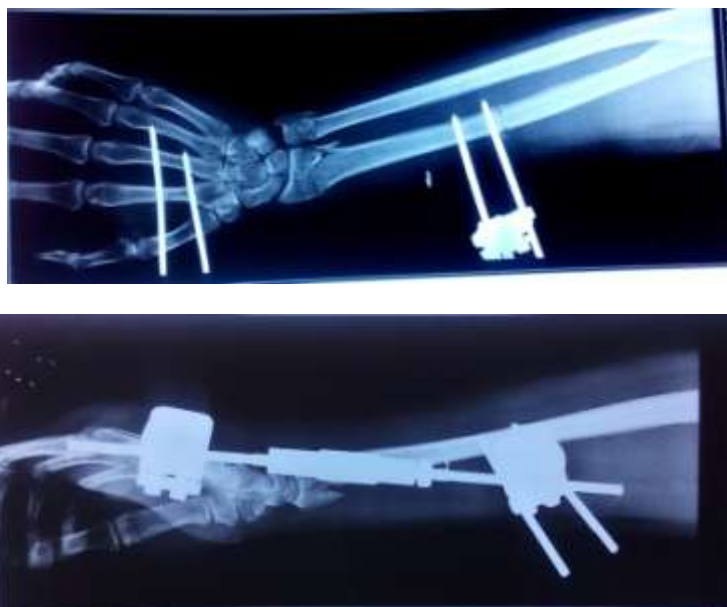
Radiograph ( AP and Lateral view) showing fracture distal radius fracture external fixator in situ
